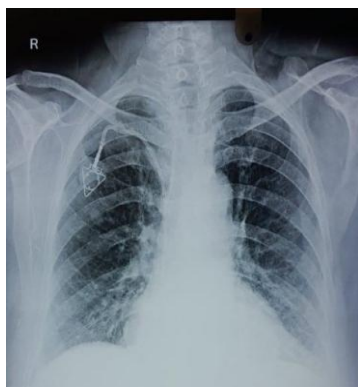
POST OPERATIVE X-RAY CHEST CONFIRMING THE POSITION OF CHEMO PORT
